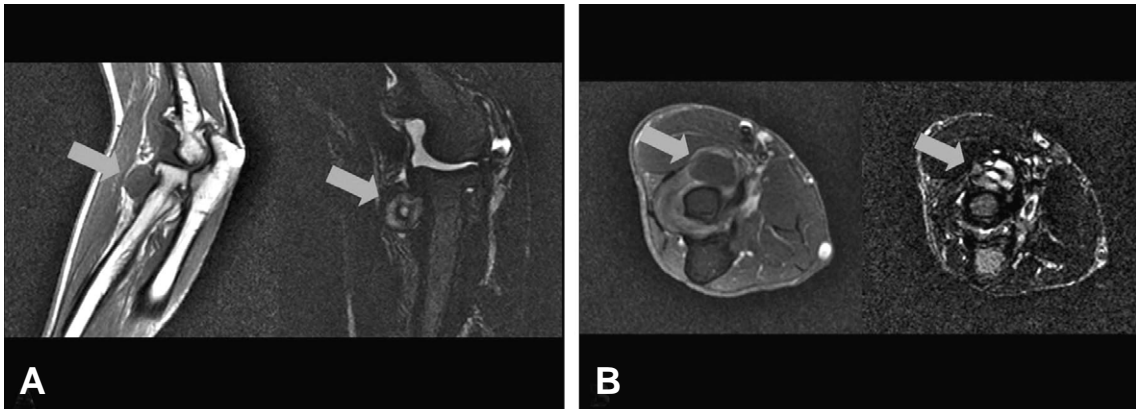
The MRI (A; sagittal view, B; axial view) shows 1.6×1.2 cm sized round mass (arrows) anterior to neck portion of the radius, the mass shows homogenous low signal intensity in T1 weighted image, high and low signal intensity in T2 weighted image.
